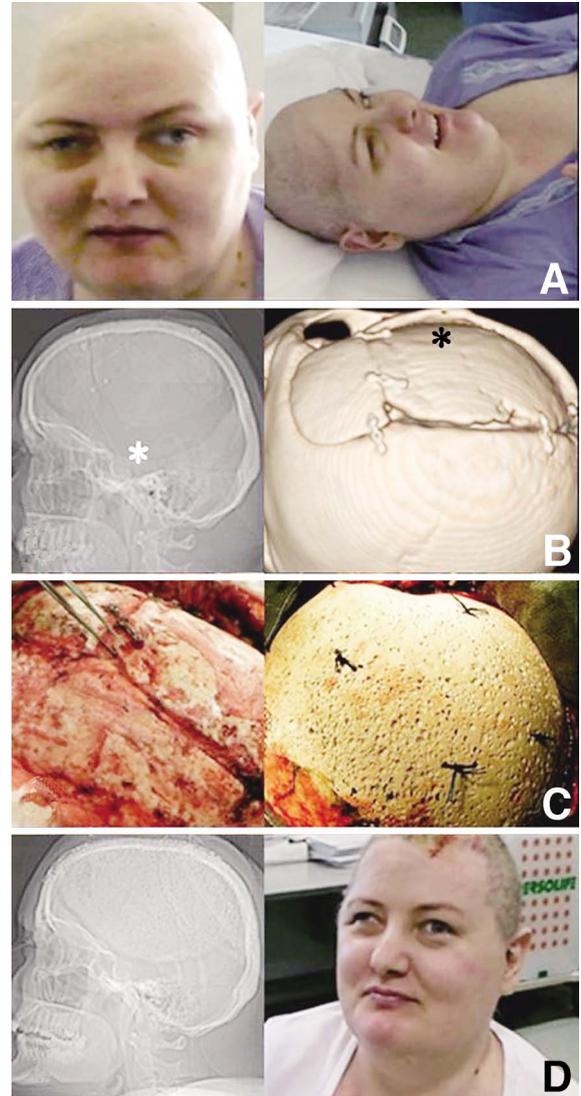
Case 2. A: Neurological examination before sinking bone correction showing right ptosis during the sitting position and its regression in the supine posture. B: Computed tomography (CT) scout view and three-dimensional CT scan demonstrating partial resorption (white asterisk) and sinking (black asterisk) of the re-implanted bones. C: Intraoperative photographs showing the re-implanted bones were thinned and freely moving over the dural layer, so they were removed and replaced with a porous hydroxyapatite implant fully covering the cranial defect. D: Post-cranioplasty CT scout view showing the correct implant positioning, and photograph showing right ptosis regression also in the upright position.
